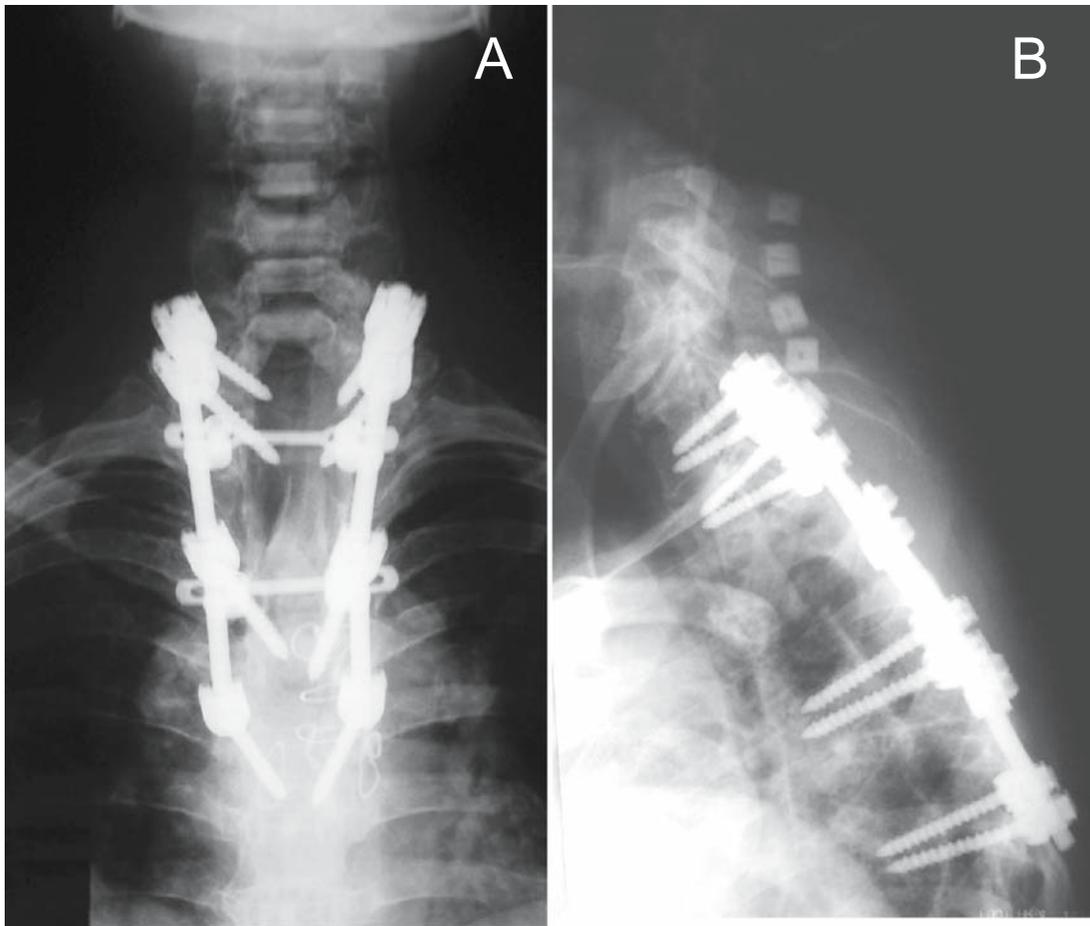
Postoperative radiographs. A Anteroposterior view. B Lateral view
